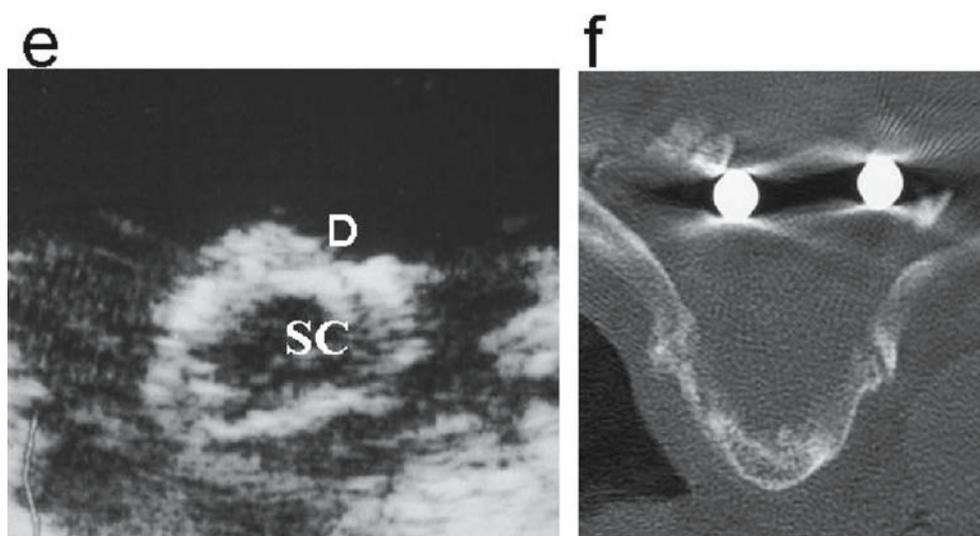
A 54-year-old woman with thoracic OPLL. a Preoperative MRI. Spinal compression by OPLL was observed at T4–T7 and by ossification of the ligamentum flavum (OLF) at T3–T4, T4–T5, and T5–T6. b Long-axis image of the spinal cord during intraoperative ultrasonography after laminectomy. No echo-free space was detected on the ventral side of the spinal cord at T5–T6, and deformation of the spinal cord was observed. *SC*, spinal cord; *PL*, posterior longitudinal ligament. c Short-axis image of the spinal cord during IOUS after laminectomy. The spinal cord was entirely flattened. Spinal decompression was judged to be insufficient, and the thoracic
